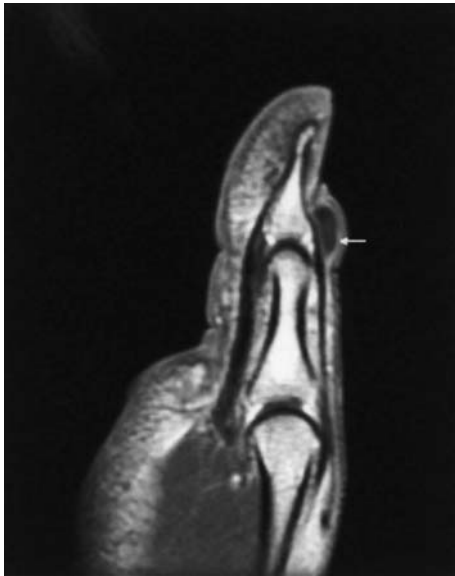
Synovial cyst. Sagittal contrast-enhanced T1-weighted SE image (TR/TE/slice thickness: 500 ms/12 ms/3 mm). The synovial lining enhances after intravenous gadolinium (Gd) administration (arrow)
